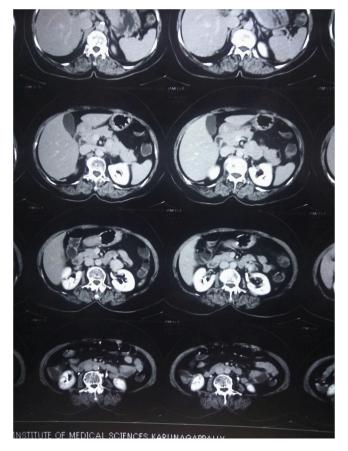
CT picture showing the tumour close to the left renal hilum attached to the left renal vein.
